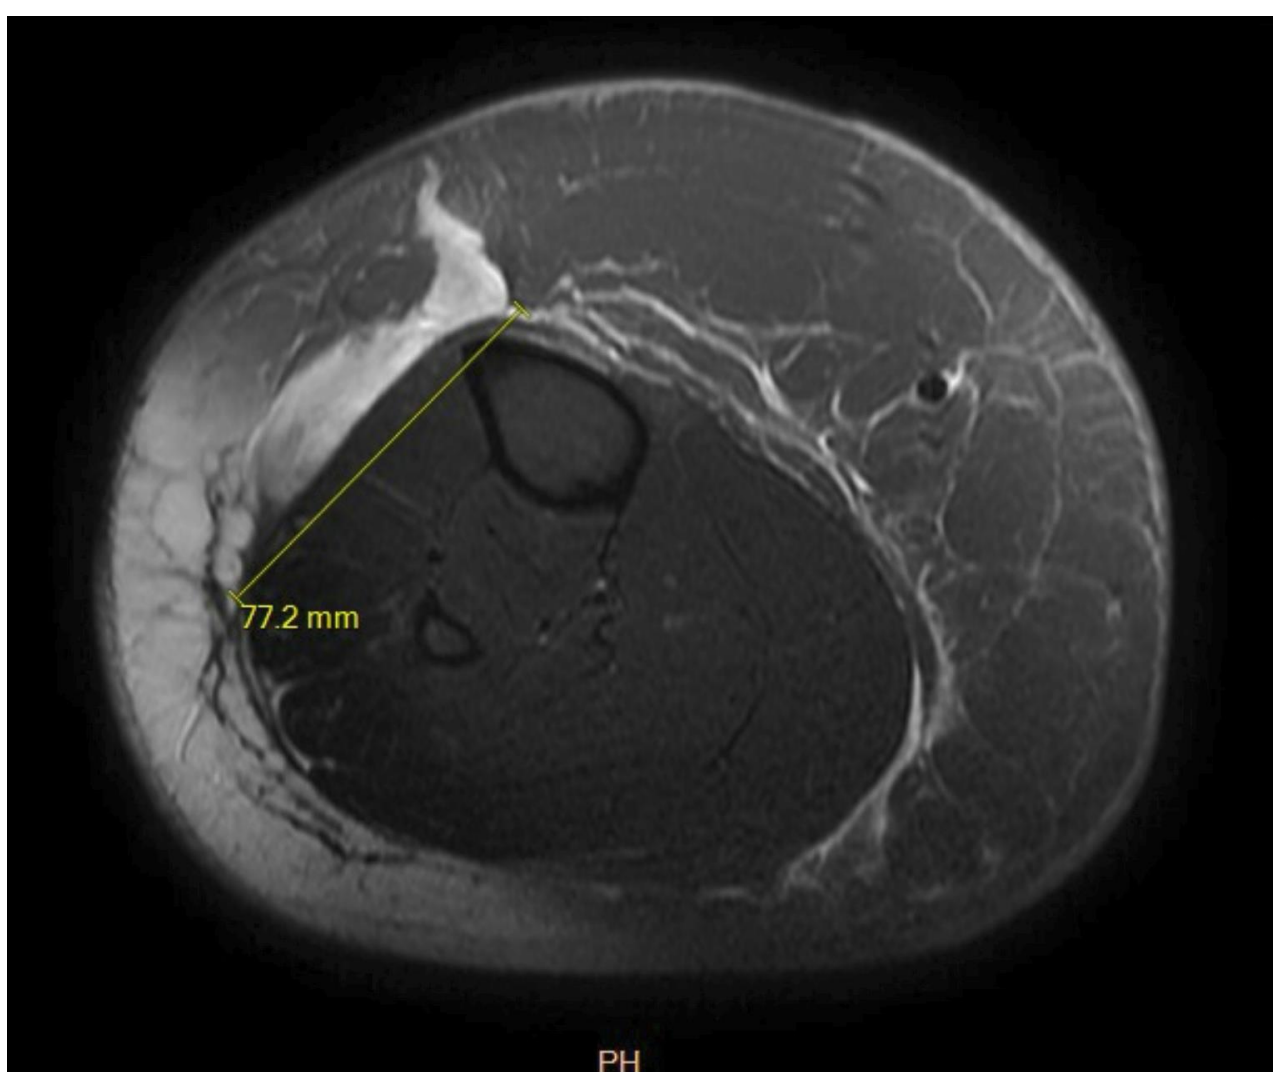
MRI T2W images of R leg in coronal, axial, and sagittal plane
